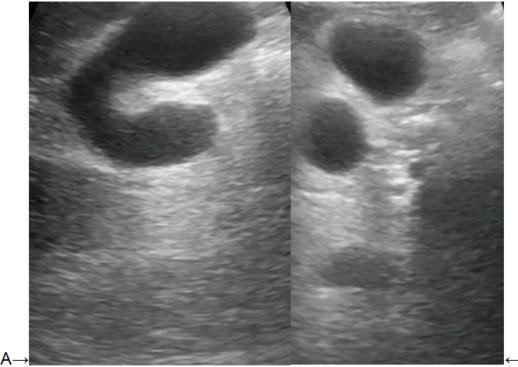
Ultrasound of gallbladder duplication: (A & B)
